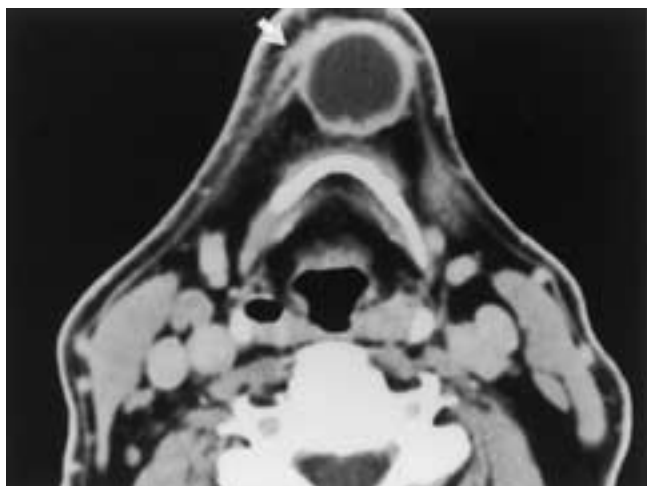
Malignant submental adenopathy in a 63-year-old male with a history of squamous cell carcinoma of the left external auditory canal 7 years earlier. Axial CT image with contrast enhancement demonstrates a midline submental cystic-appearing lesion interpreted initially as a thyroglossal duct cyst. The enhancing margin, however, has irregular thickness and is “stranded” (arrow), the overlying fat is “dirty” in appearance, and the skin is thickened. Contrast this appearance with that of the thyroglossal duct cyst in Figure 27-25.
